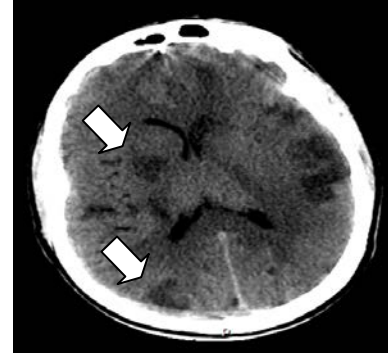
A CT of the head revealed multiple thromboembolic lesions (arrows).
